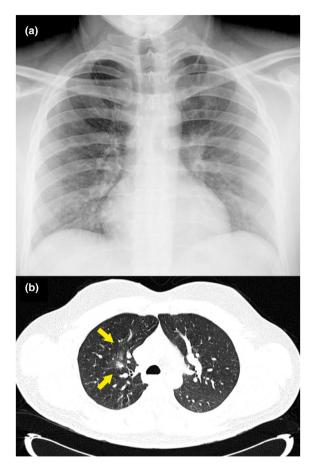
Radiological images. (a) Chest radiography showing radiopacities in the base of the right lung. (b) Thoracic computed tomography showing confluent nodules with a peripheral ground glass halo, suggesting viral infection but not suggesting COVID-19 pneumonia
